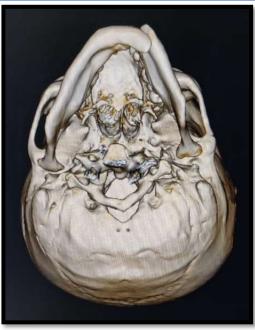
3D Reconstruction of Computed Tomographic Scan revealing non – union of fractured segments along with eburnation of the bone.
